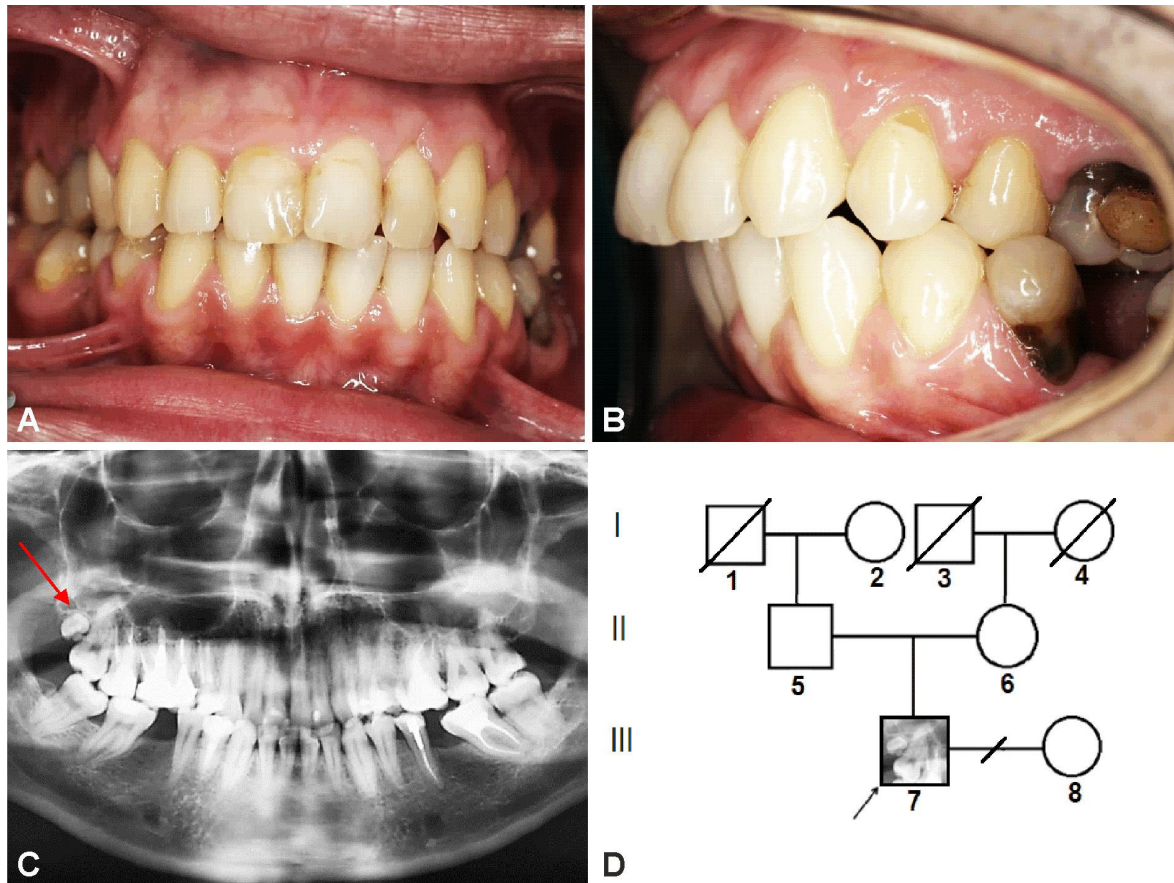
Impacted upper permanent distomolar (1.8 bis) – isolated, sporadic, non-hereditary, nonsyndromic case (33-year-old male). Intraorally in occlusion: frontal (A) and lateral (B) views revealing the clinical dental phenotype; panoramic radiograph showing the supernumerary tooth (C); the family tree: isolated, sporadic case (D).
